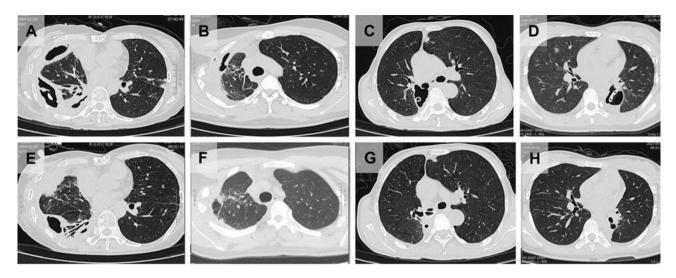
The comparison of representative CT scans before and after culprit bronchi occlusion. The upper and lower rows are CT scans before (A–D) and after (E–H) treatment respectively. The column from left to right, is the CT scan of patients using Vaseline gauze (case 4, A, E), shape-adjustable silicone plug (case 9, B, F), sutured silicone tube (case 13, C, G) and covered metallic stent (case 14, D, H)
